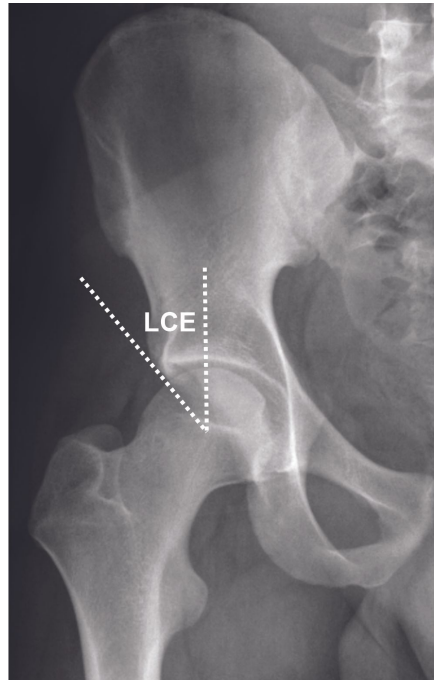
Lateral Center Edge Angle. A pincer-type femoro-acetabular impingement may be due to an increased Wiberg Lateral Center Edge (LCE) angle ($>33^\circ$), which is assessed on the frontal pelvic radiograph.
